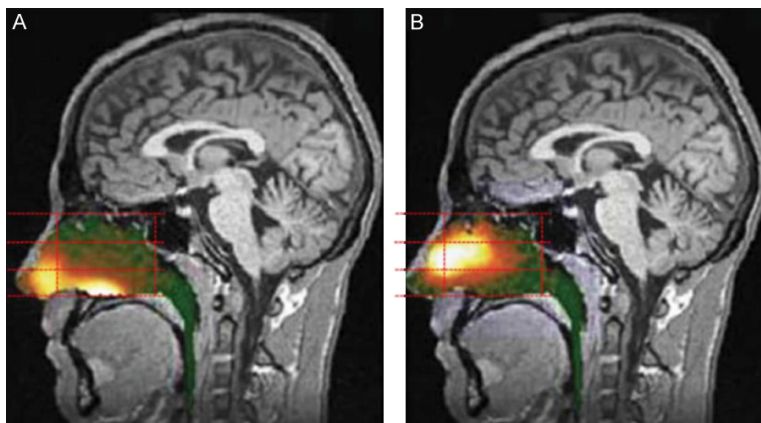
Gamma scintigraphy of an example of a breath-powered nasal spray. (Figure included with permission from Djupesland et al., 2013.) Gamma camera images 2 minutes after delivery using a traditional liquid spray (A) and powder with OptiNose Breath-Powered Device (B) shown with a logarithmic hot iron intensity scale. Initial gamma images from one of the subjects are esuperimposed on a lateral MR image. The red dotted lines indicate the segmentation used for regional quantification.
